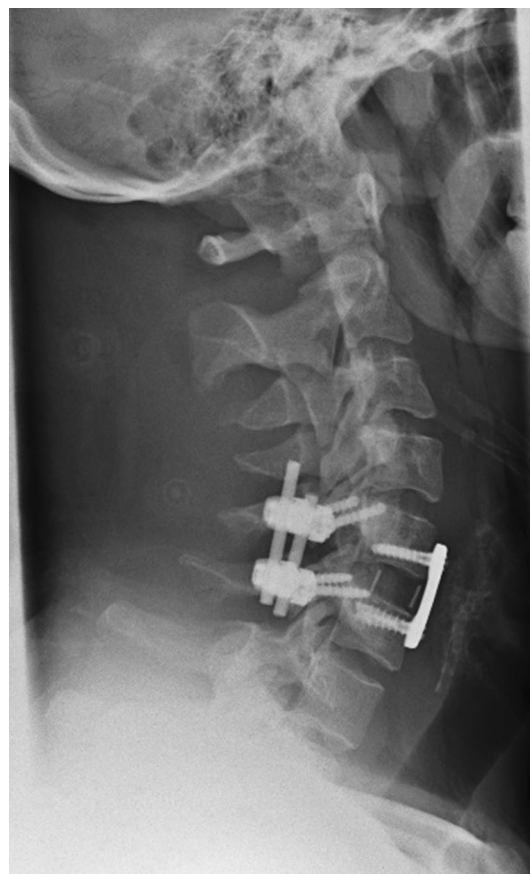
Post-operative cervical X-ray at 3 months
